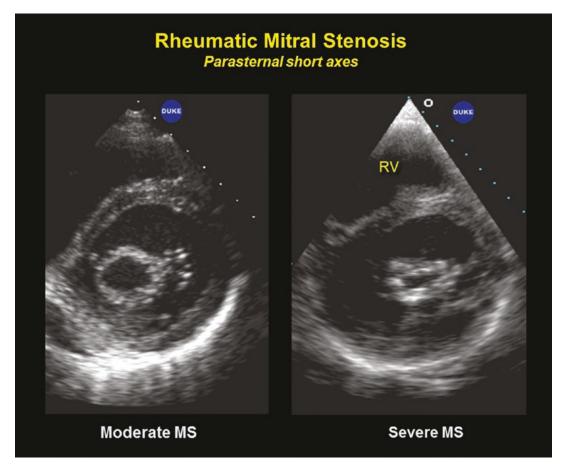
Parasternal two-dimensional diastolic short axis still frames from a patient with moderate (left) mitral stenosis compared to one with severe mitral stenosis (right)
